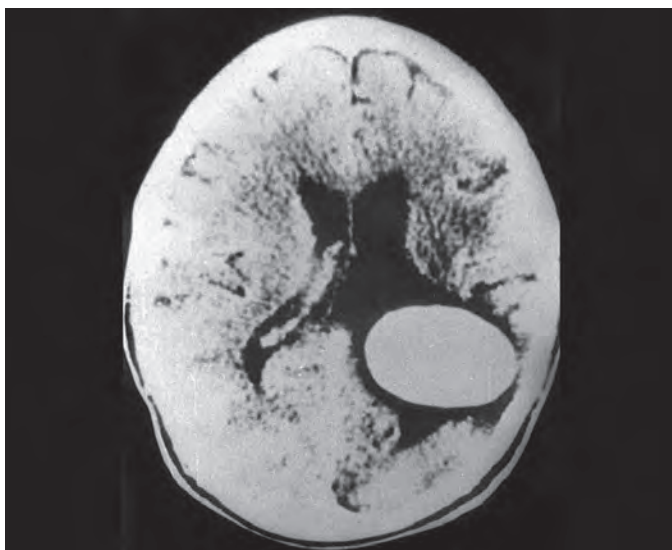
CT scan of the brain shows well circumscribed lesion in the trigone of the lateral ventricle
